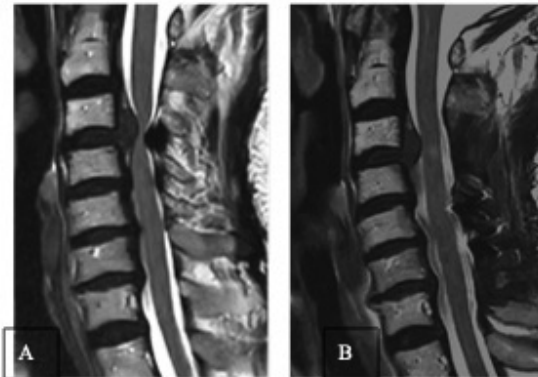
Case presentation: A 70 years-old female complicated with coronary heart disease presented with bilateral hand clumsiness, bilateral arm numbness, trunk numbness, lower limb extremities numbness and weakness in both legs. The preoperative mJOA score was 7.5. Sagittal view on MRI showed cord compression at C3/C4, C4/C5, C5/6 and C6/7 (Figure 2A), LAMP at C3–C7 was performed. At 3 months postoperatively, the C3/4 showed RASCC (Figure 2B) and the RR of mJOA was 73.68%. While she still had bilateral arm numbness and numbness in both feet. The second-stage C3/4 ACDF was performed and the JOARR increase to 94.73%.
